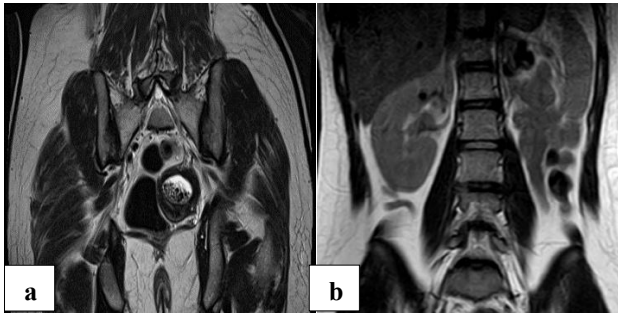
(a and b): Coronal T1 MRI showing absent left kidney and left hematocolpos.
